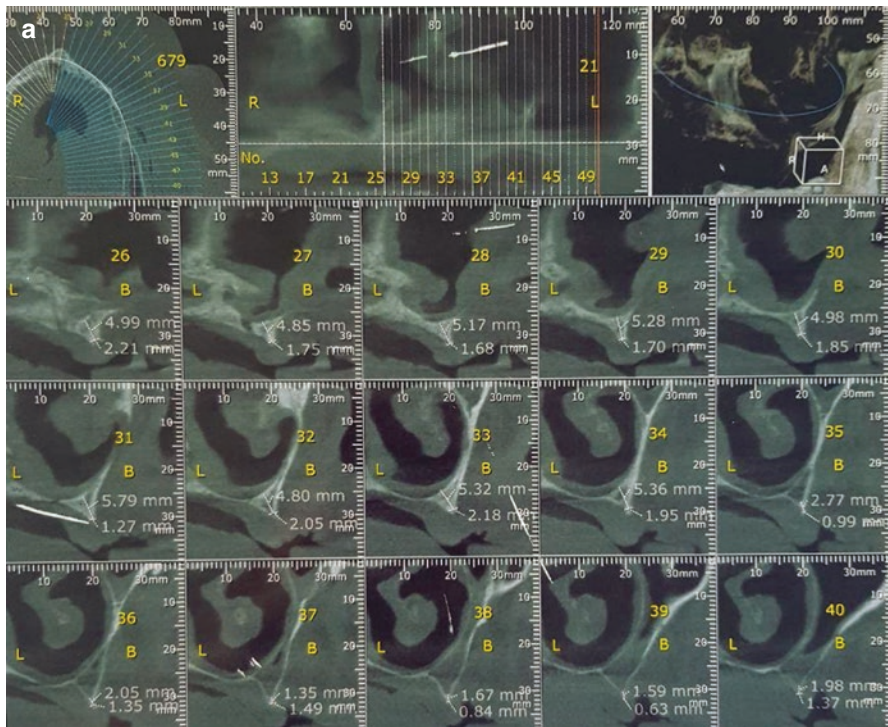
CBCT of patient with severe maxillary alveolar ridge atrophy. Note the insufficient bone width and height (a). A full-thickness mucoperiosteal flap is elevated to expose the maxillary bone (b). Cortico-cancelous bone is harvested from the anterior iliac crest. Cortico-cancelous bone blocks harvested from the anterior iliac crest are fixated on the maxilla with titanium miniscrews to augment bone width and height. The buccal fat is approached and pulled over the grafted sites while preserving its intact pedicle for blood supply to boost soft tissue healing and increase the chances for graft survival (d, e). Platelet-rich fibrin (PRF) plugs derived from the patient’s centrifuged blood sample are prepared and placed over anterior grafted sites where the buccal fat could not reach (f). Grafted cortico-cancelous bone blocks covered with bilateral buccal fat grafts and PRF plugs (g). Healed soft tissue 3 months after the operation. Note the lack of adequate keratinized gingiva buccal to the alveolar crest (h). Post-op OPG after bone grafting (i). In the second-stage surgery, palatal keratinized gingiva is transferred to the buccal of the healing abutments by a beveled incision placed palatal to the alveolar crest. The gaps between the keratinized tissues will heal secondarily (j, k). Post-op OPG after implantation (l)
